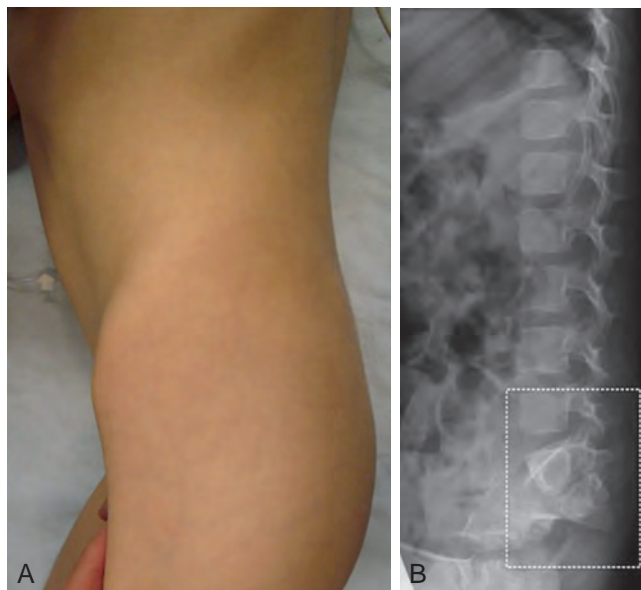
Sacral agenesis. A, Findings on physical examination, including a “flat” appearance of the buttocks, associated with neuropathic bladder and bowel. B, Lateral-view lumbosacral radiograph with bony defects of the lower spine consistent with sacral agenesis (or caudal regression syndrome).
